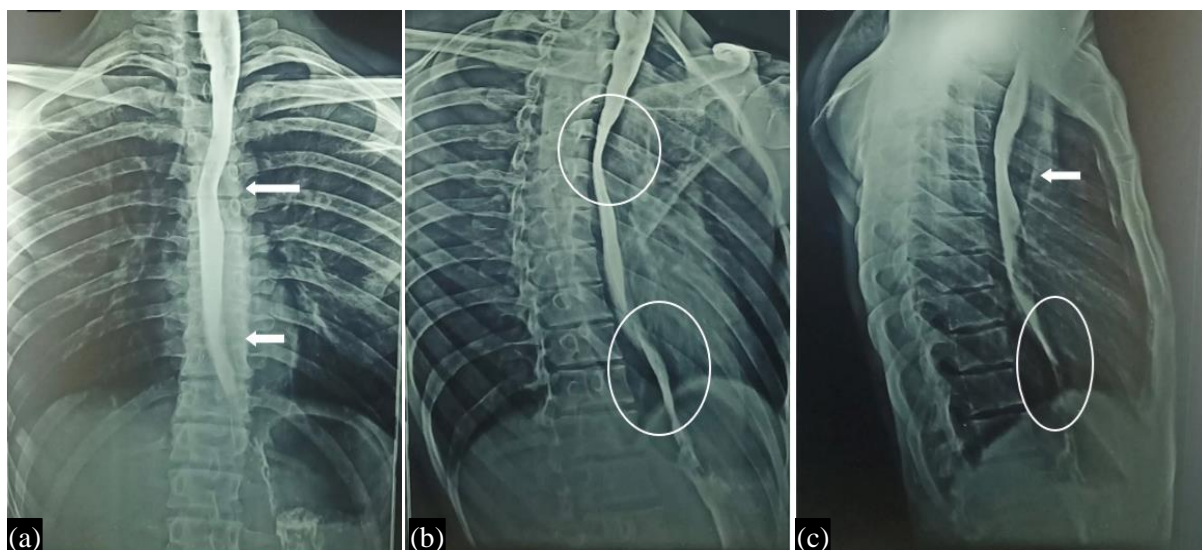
Barium swallow X-rays: Barium swallow studies show the fluid accumulation in the esophageal region with dilation of upper (24/07/23), (a) AP View, (b) Esophageal dilation and stricture (c) Lateral view.
